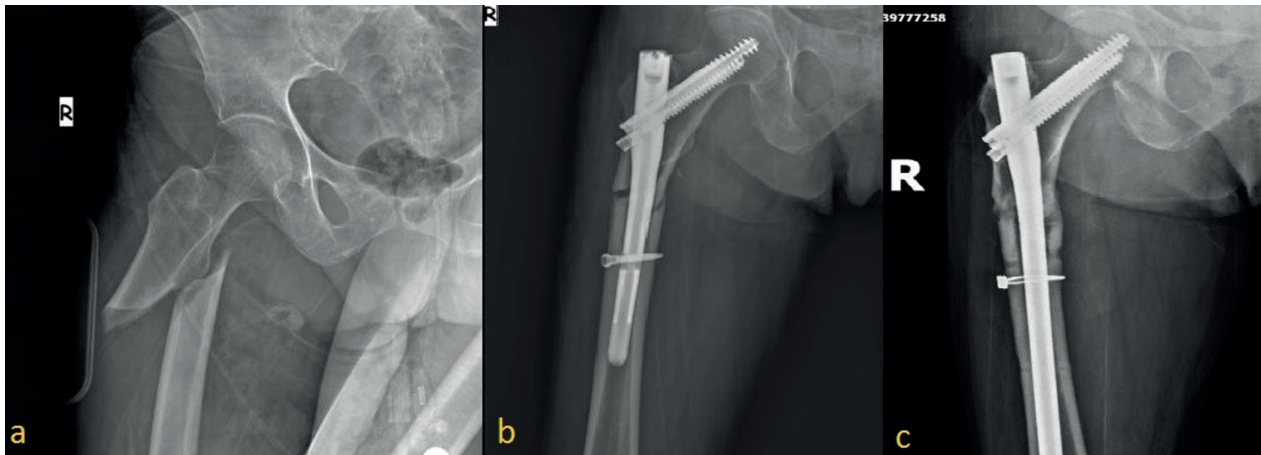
a) 37 years old female patient, motor vehicle accident, preoperative x-ray. b) Postoperative 1st month x-ray, fixation with 3 cables, 3 mm gap laterally. c) Postoperative 5th month, complete union.
